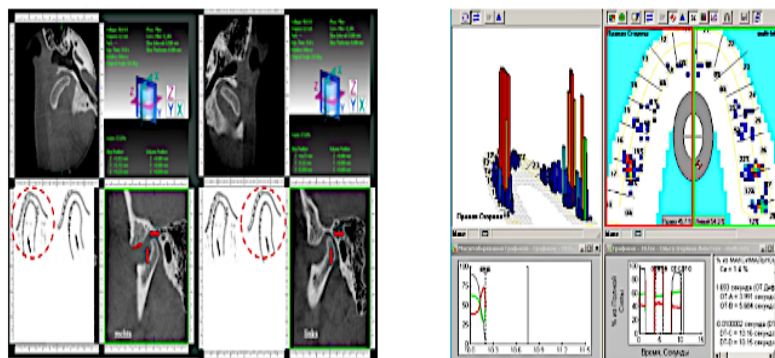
On 3D CT (left), dorsal displacement of both TMJs is observed; on the right, digital static occlusion analysis shows excessive posterior tooth contact on both sides and disproportionate loading on dental arches (right 45.7%, left 54.3%)
